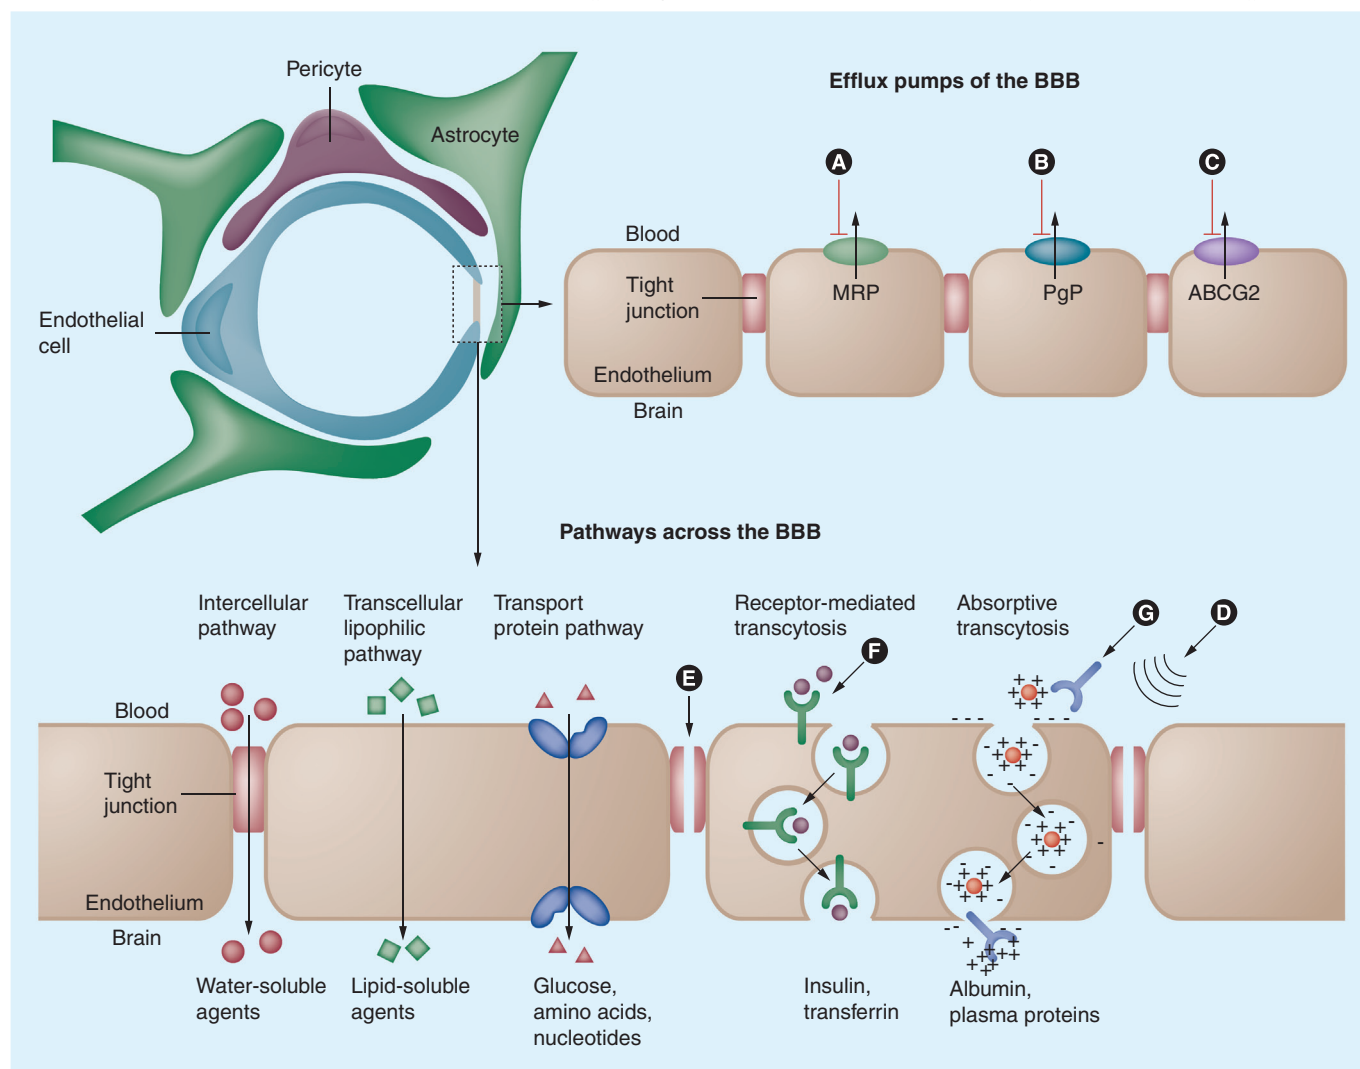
Approaches to enhance drug delivery to the brain. The main drug efflux transporters of brain capillary endothelial cells include MRPs, PgP and ABCG2. All of these transport proteins have been targeted for pharmacological inhibition. The action of (A) probenecid, sulfinpyrazone and MK-571; (B) verapamil, cyclosporin A, quinidine, valsopodar, elacridar, biricodar, zosuquidar and tariquidar; and (C) GF120918 (elacridar) and fumitremorgin C. Tight junctions normally restrict the penetration of water-soluble compounds across the BBB, but they can be disrupted by mechanical and pharmacological methods via (D) ultrasound and (E) bradykinin analogs, respectively. (F) Receptor-mediated transcytosis of transferrin or insulin has been used to increase the transport of drugs across the BBB and (G) cationization (i.e., antibodies) can increase uptake of molecules by absorptive transcytosis. BBB: Blood–brain barrier; MRP: Multidrug resistant protein; PgP: P-glycoprotein.
